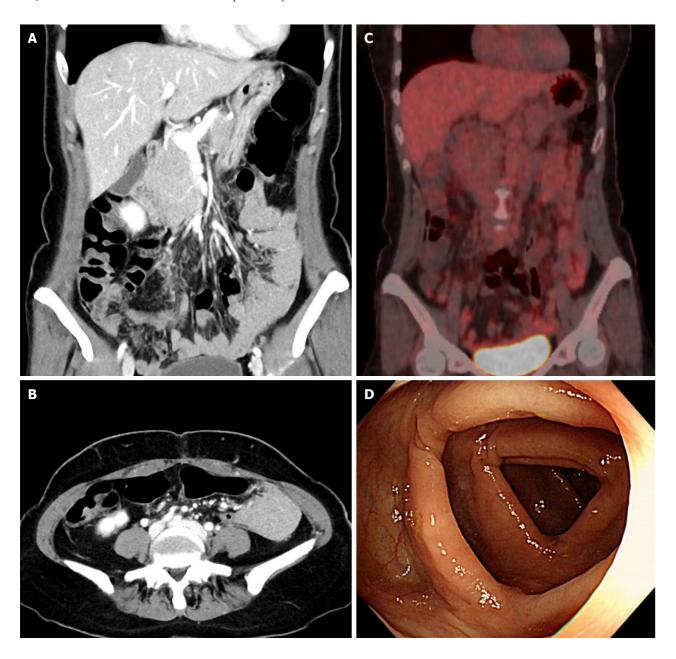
Postoperative imaging and endoscopy findings. A and B: Postoperative abdominal-pelvic computed tomography scans show no detectable intraabdominal masses; C: Postoperative positron emission computed tomography-computed tomography reveals no abnormal hypermetabolic lesions suggestive of malignancy; D: Postoperative colonoscopy demonstrates no abnormal lesions in the colon.
